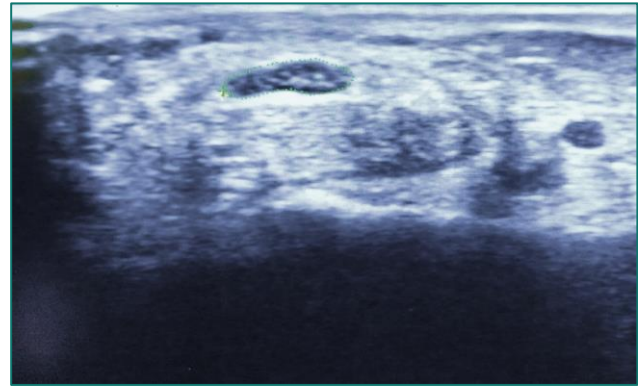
Transverse sonogram of the median nerve at the carpal tunnel inlet
